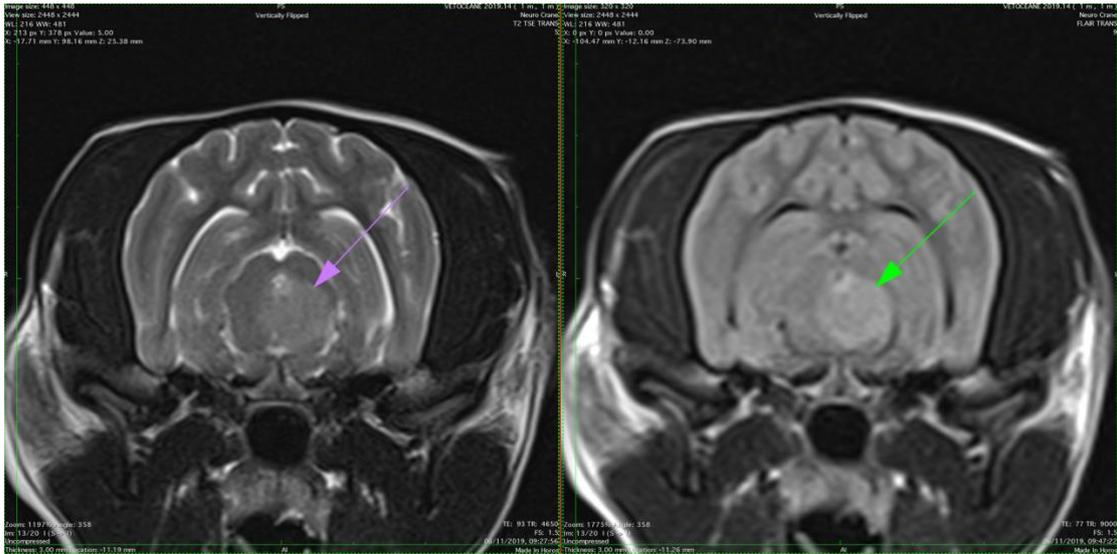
Trv T2W (left) and T2-FLAIR (right) rostral colliculi
